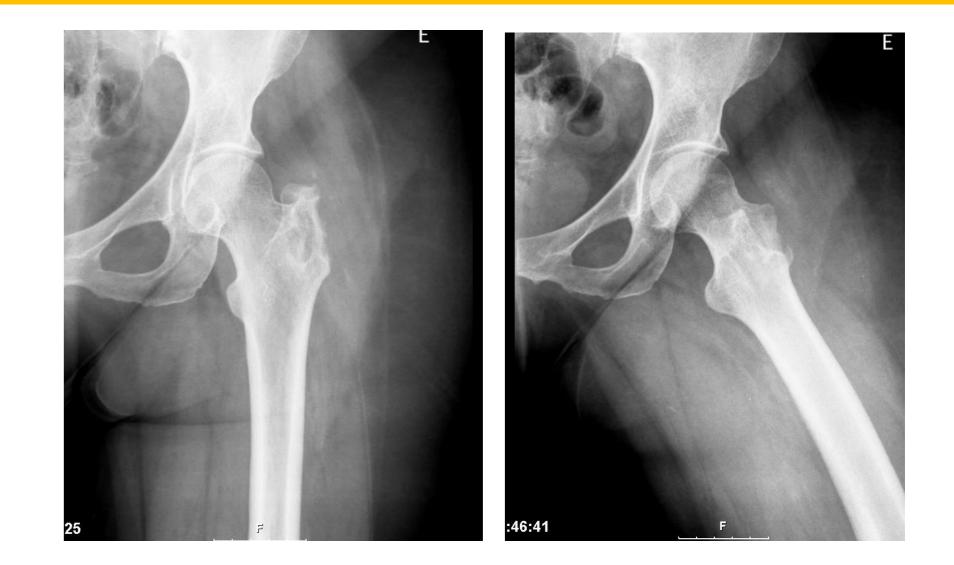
Plain radiograph – 2y follow up [remodeling of the bone structure]
